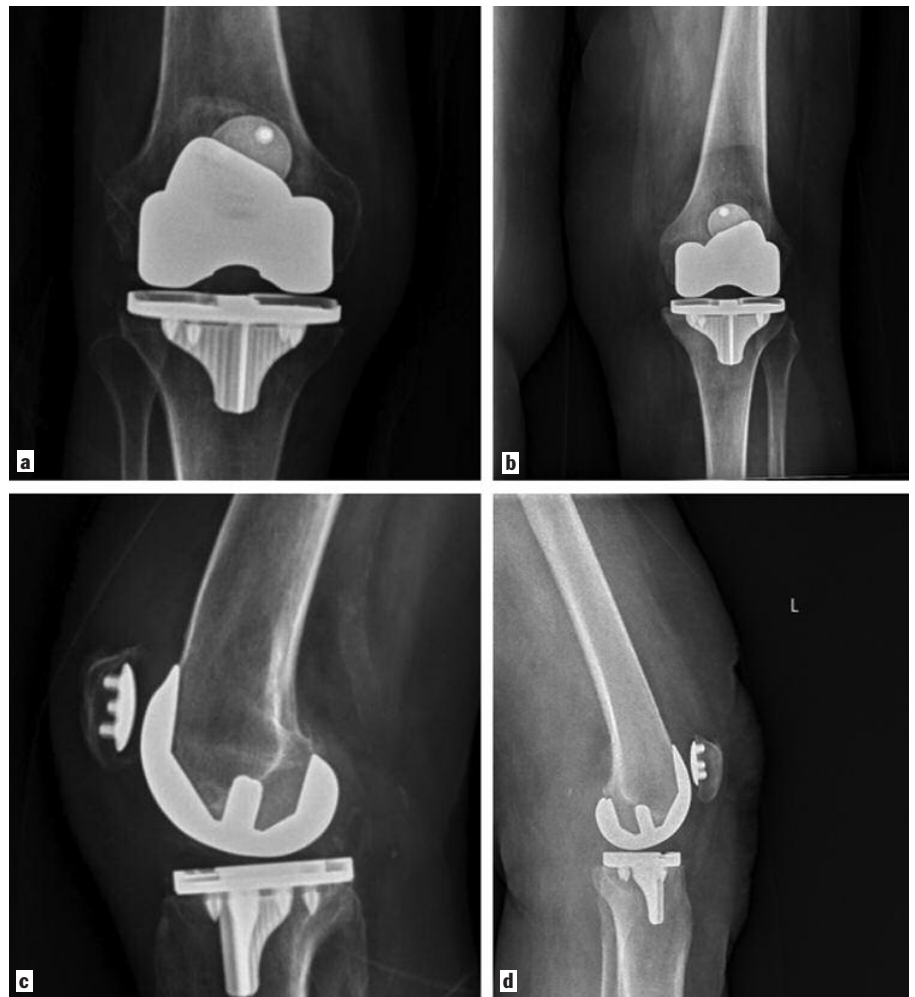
Antero-posterior, (b) lateral radiographs, and sunrise views demonstrating (c) well-positioned and (d) well-aligned.
